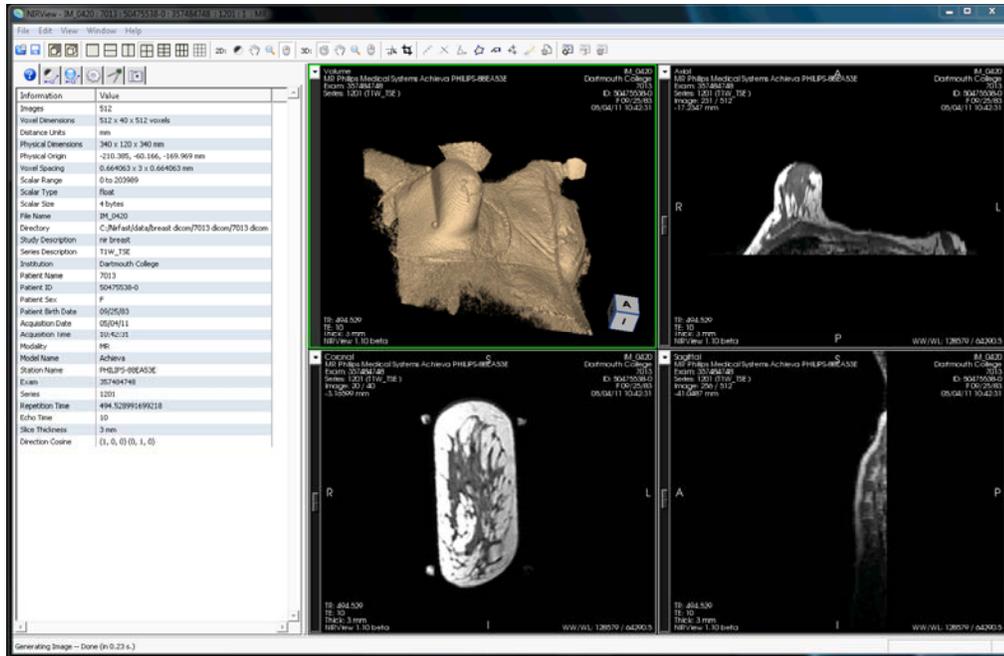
The NIRFAST tool for segmentation of MR/CT DICOMs as produced in collaboration with Kitware Inc. This is the starting point for a higher-end GUI for expert users, allowing high flexibility in segmentation & mesh creation for input.
